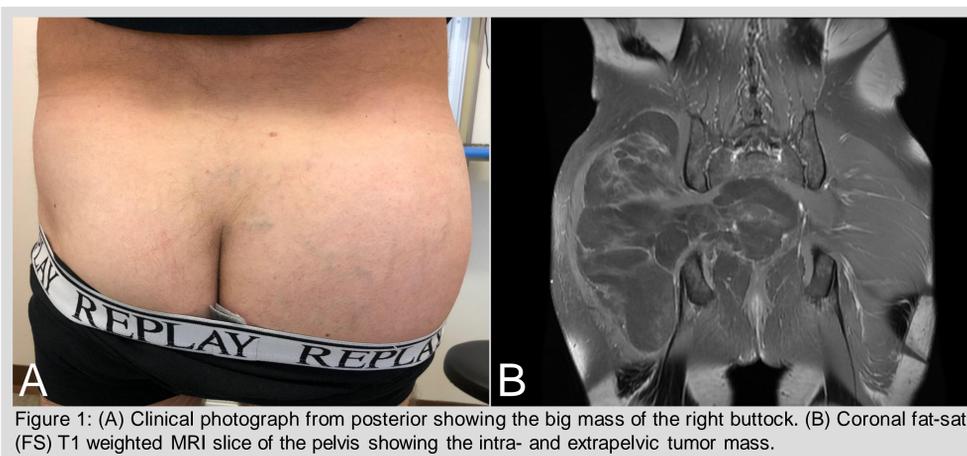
(A) Clinical photograph from posterior showing the big mass of the right buttock. (B) Coronal fat-sat (FS) T1 weighted MRI slice of the pelvis showing the intra- and extrapelvic tumor mass.
